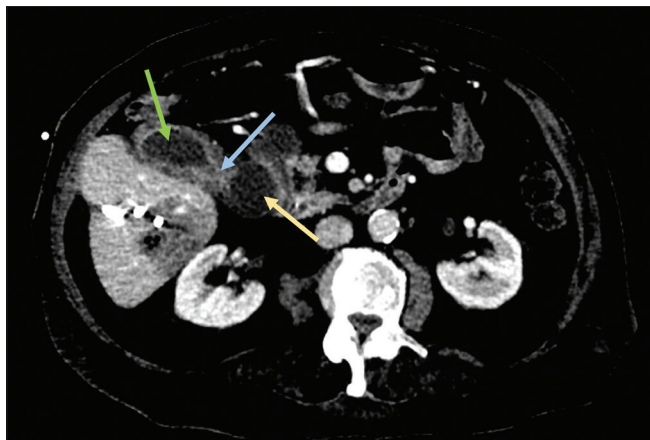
Transaxial section from abdominal computed tomography showing dumbbell gallbladder with a partial stricture (blue arrow) creating a proximal end (yellow arrow) and distal end (green arrow). Posteroinferior hepatic abscess is also demonstrated
